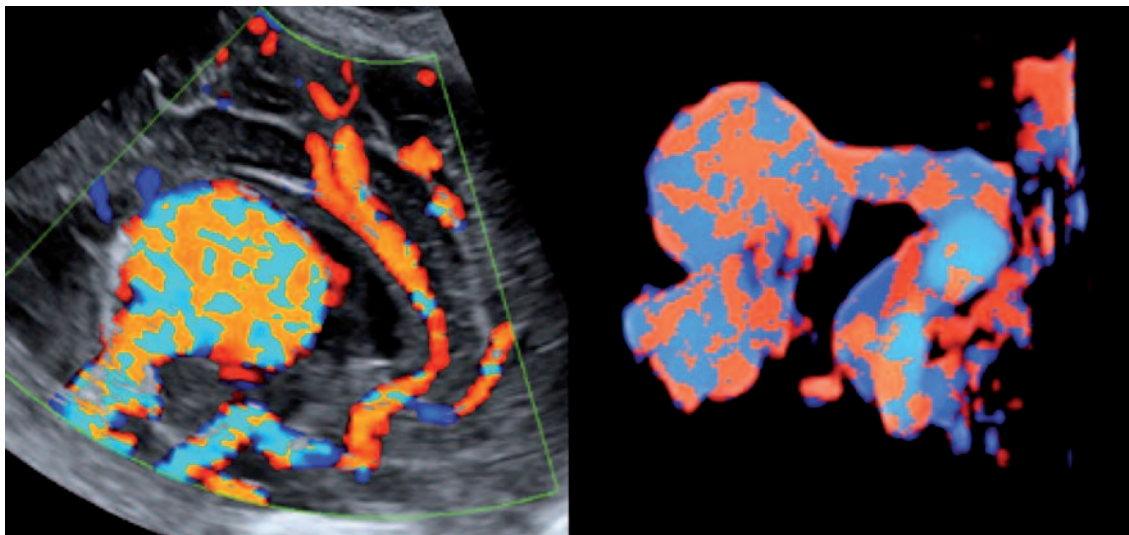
Vascular anomalies are uncommon, but the most frequently seen on prenatal ultrasound is the arterio-venous malformations of the vein of Galen. 3D color Doppler imaging allows to create a 3D rotational cast of the A-V malformation.
